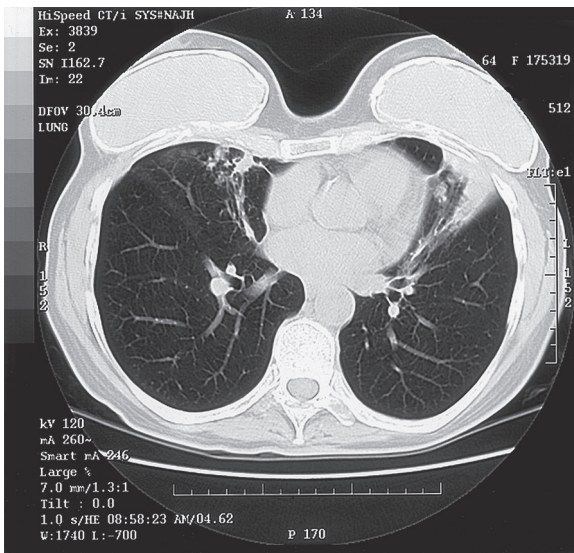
■ Computed tomography scan of a woman with *Mycobacterium avium* complex infection of the right middle lobe and lingula.
